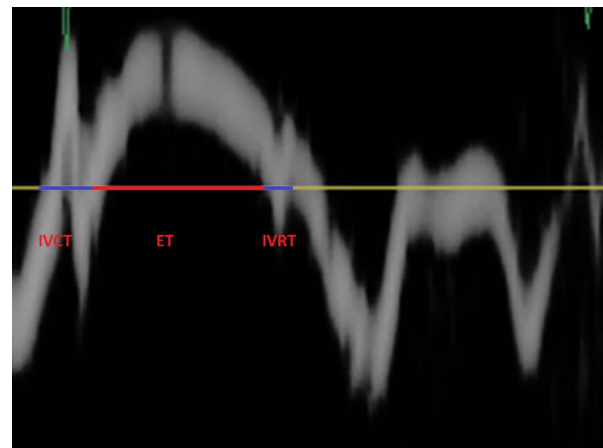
Tissue Doppler waveform showing measurements for calculation of myocardial performance index (see text).
